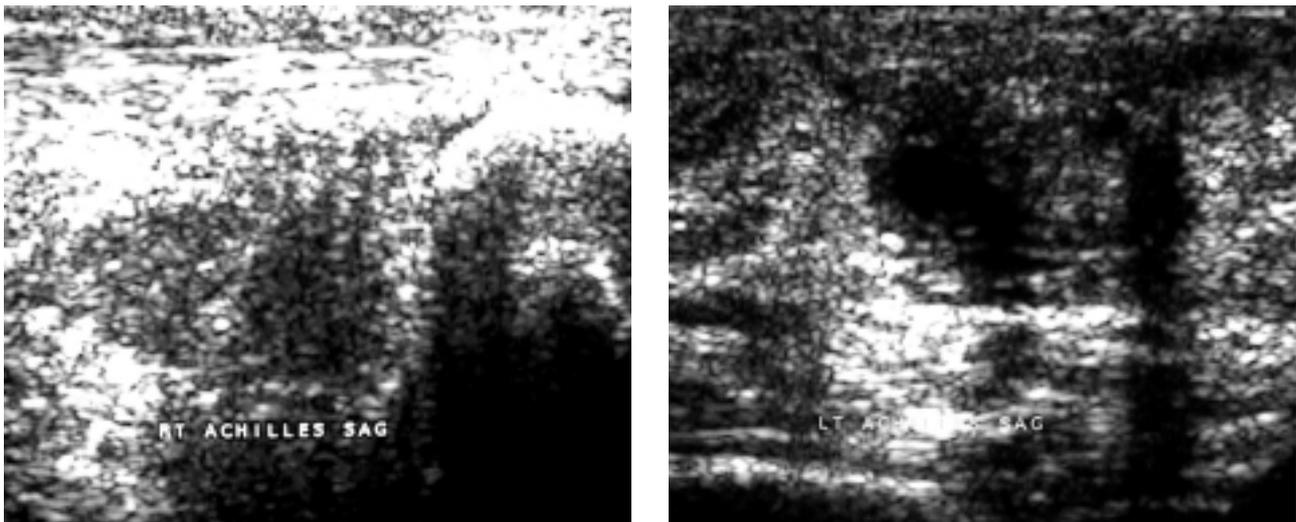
Ultrasound scans of the right intact Achilles tendon and of the ruptured left tendon.
